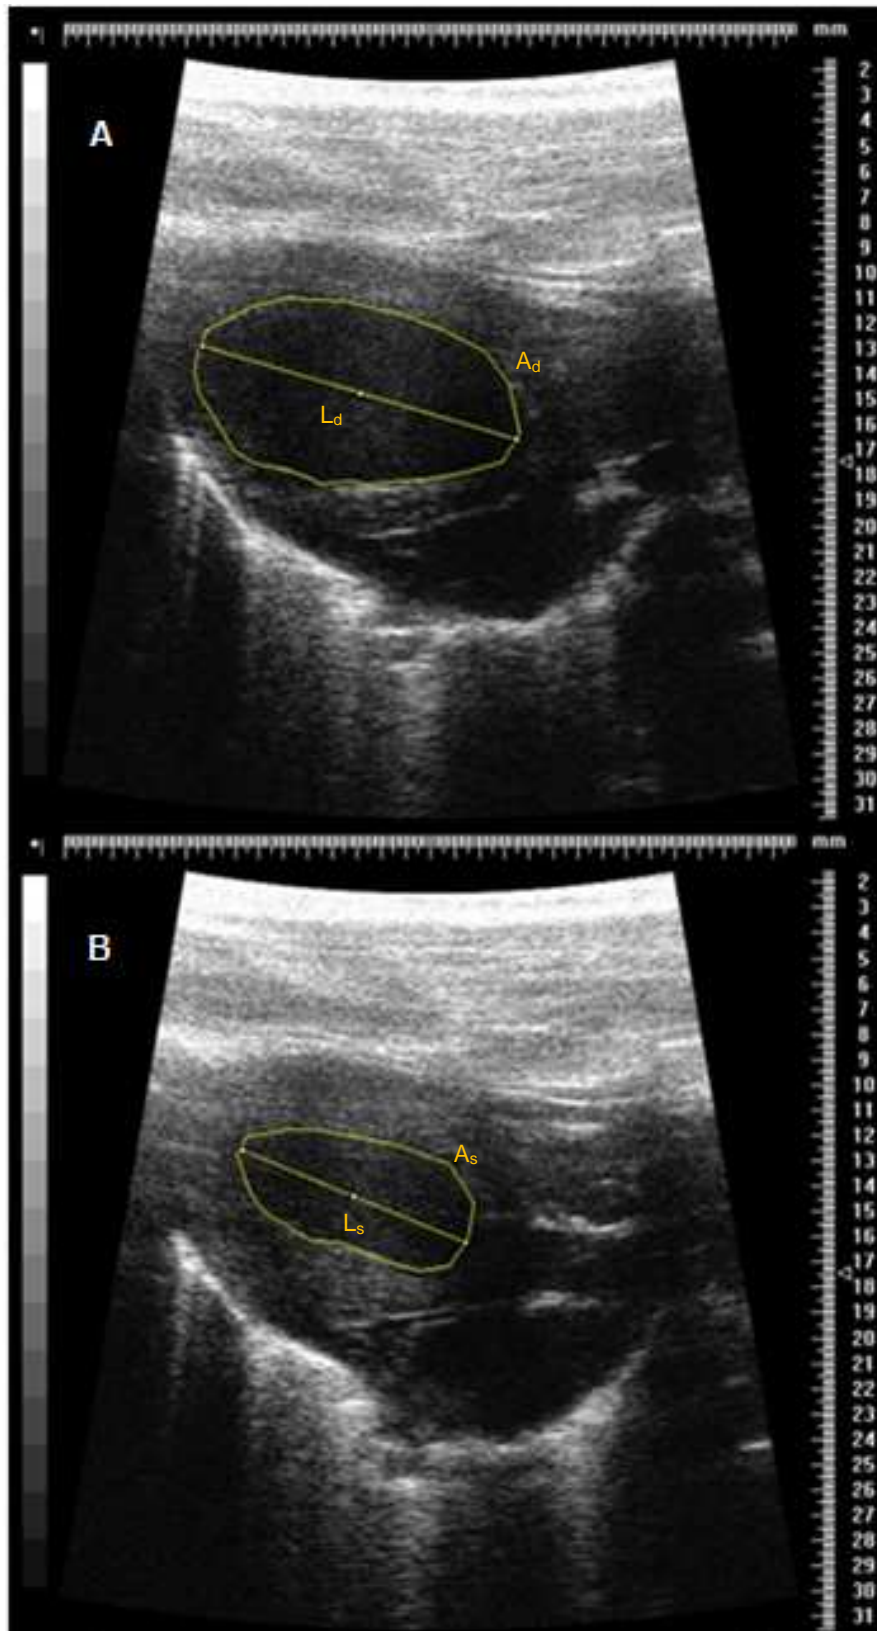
Diastolic and systolic left ventricular measurements. LV area and major axis are determined in parasternal long axis view during diastole (A) and systole (B). Both measurements from the same cardiac cycle and the same movie figure 6 was taken.
